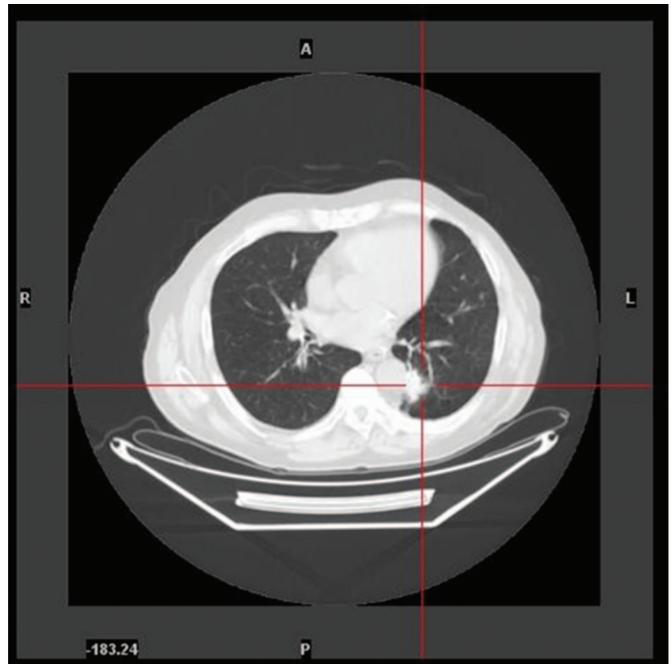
Computed tomography scan showed a left infra-hilar opacity next to the surgical site.
